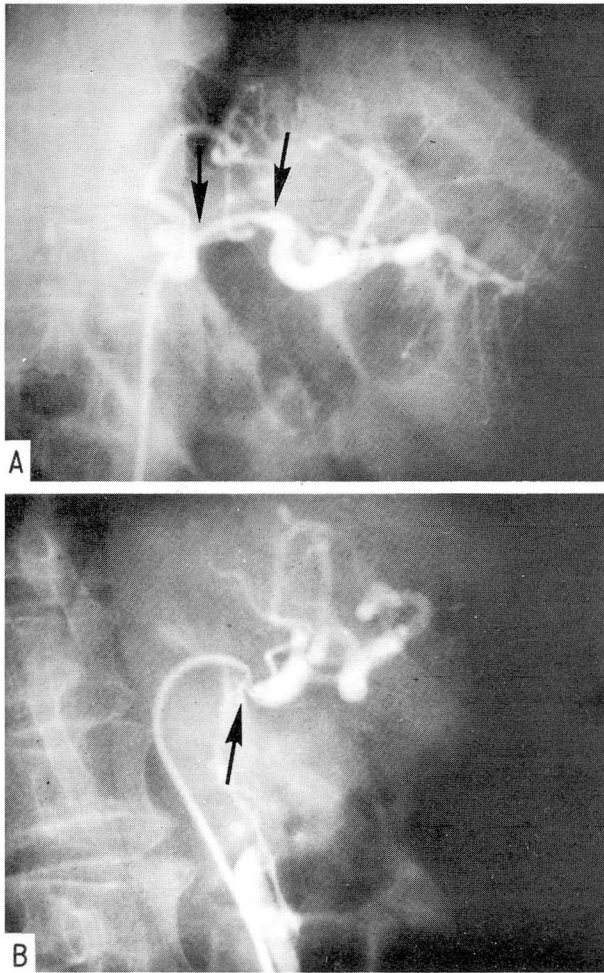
A, Anteroposterior radiograph of the celiac arteriogram showing a long segment of narrowing of the splenic artery (arrows). In this patient, the hepatic artery was derived from the superior mesenteric artery. B, Lateral radiograph of the celiac arteriogram demonstrating marked encasement of the root of the celiac axis.
